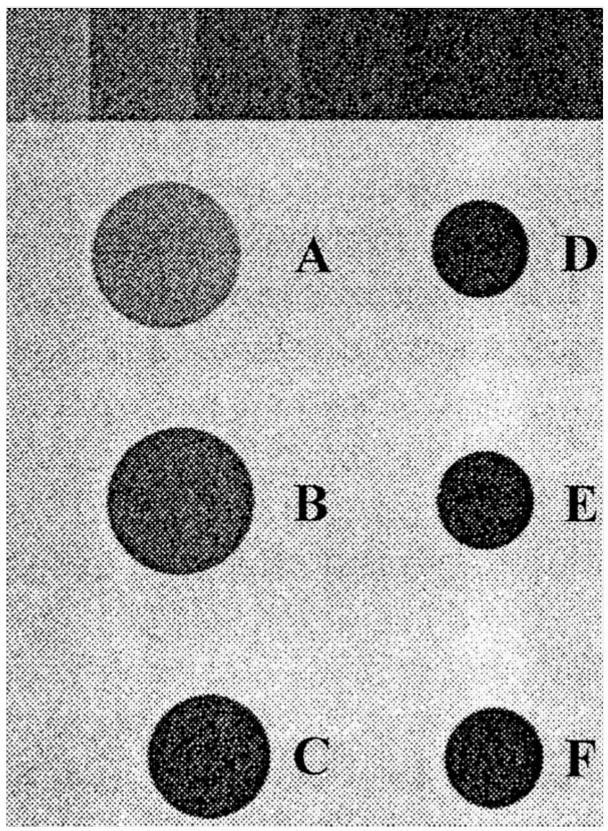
Variations of radiopacity with thickness of material. Positive radiograph of a homogeneous PMMA 20 wt-% BiBr₃ (2% resin cross-linked); thickness: (A) 1.0 mm; (B) 1.85 mm; (C) 2.9 mm; (D) 4.0 mm; (E) 5.0 mm; (F) 5.7 mm. (modified from Silberman-Hazony et al.) 8
